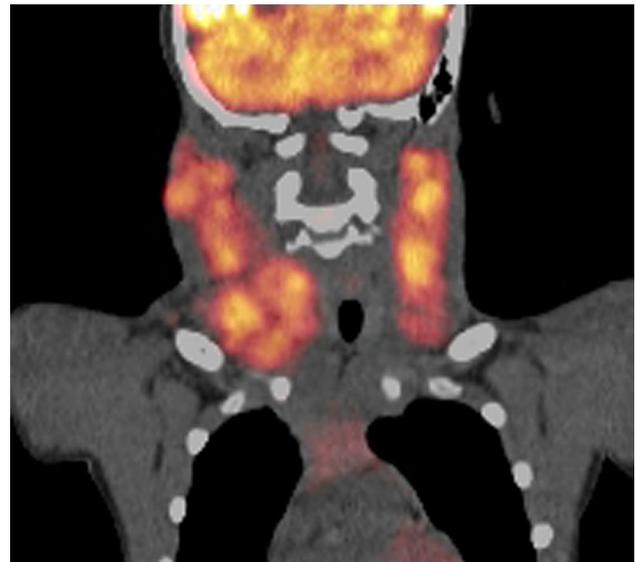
Coronal fused ^{18}F FDG-PET/CT image at 3 months follow up shows hypermetabolism associated with the bilateral cervical lymphadenopathy
